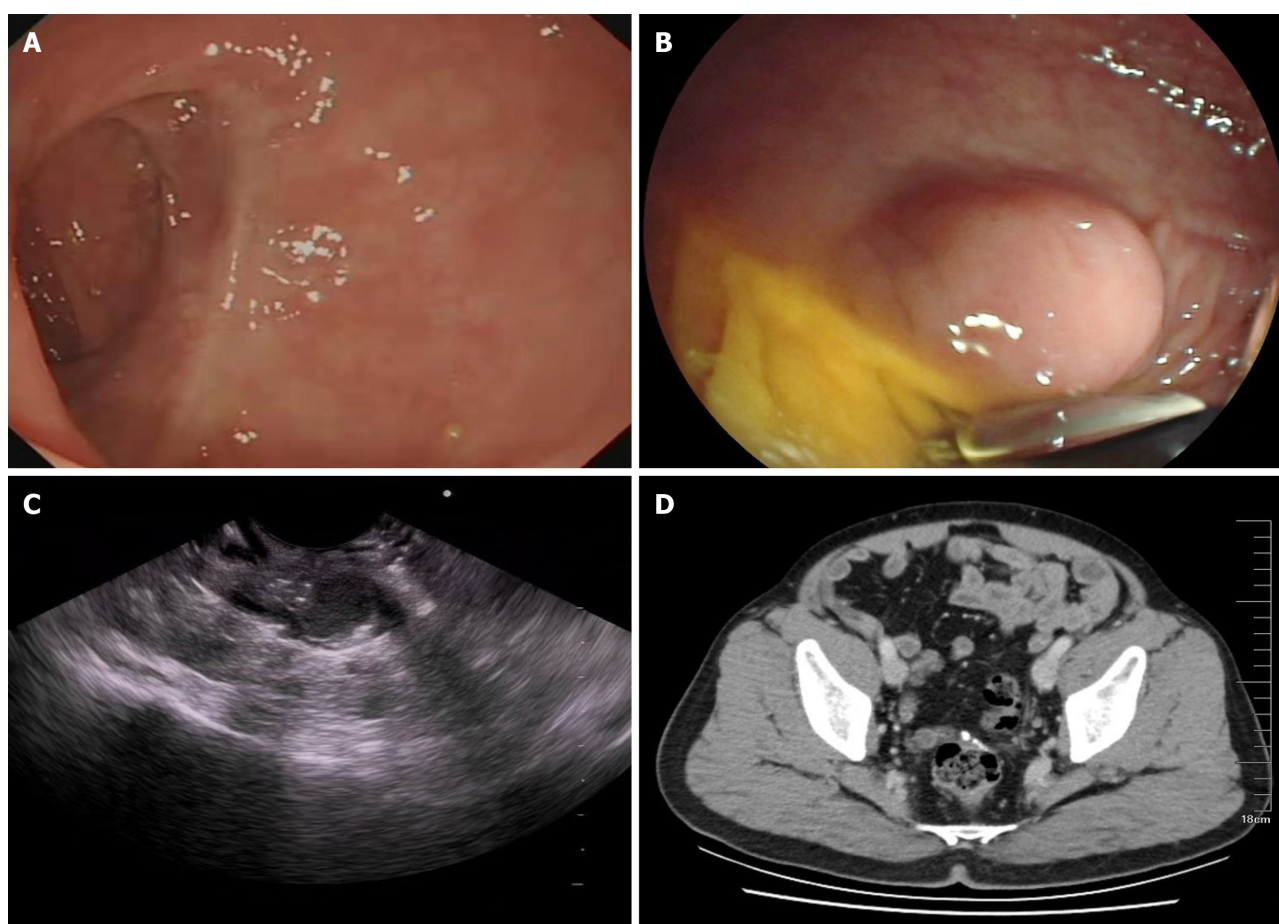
Anastomotic site findings. A: Previous colonoscopy showing no abnormalities near the anastomotic site; B: Last colonoscopy performed at the local hospital showing a smooth protuberance near the anastomotic site; C: Endoscopic ultrasound image showing a hypoechoic structure in the rectum; D: No obvious thickening or strengthening of the anastomotic wall was visible in the contrast-enhanced computed tomography scan of the pelvic cavity.
